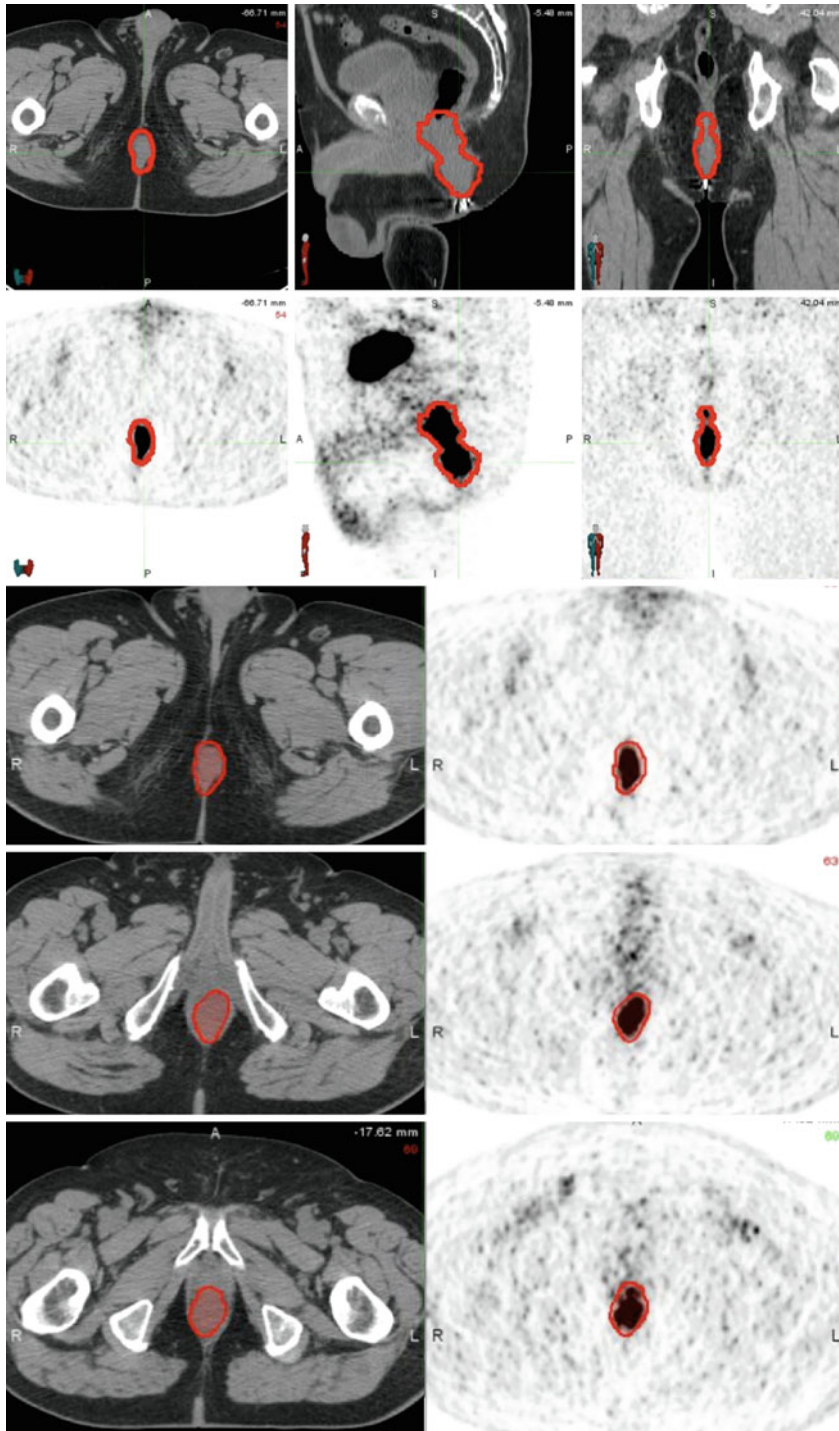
An example of how PET can help delineate GTV. The GTV (red) is seen on representative axial, sagittal, and coronal images, respectively, on both the treatment planning CT and PET in the upper panels. Additional representative axial slices are shown below in the lower panels
